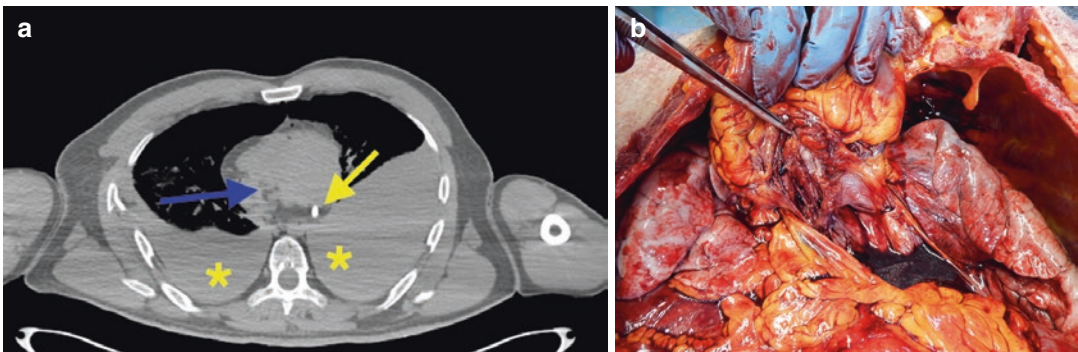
(a) Unenhanced CT after a motorcycle accident shows the presence of a wide hematic pleural effusion due to the direct chest blunt trauma. It is also possible to recognize the presence of a cardiac bypass verified at
